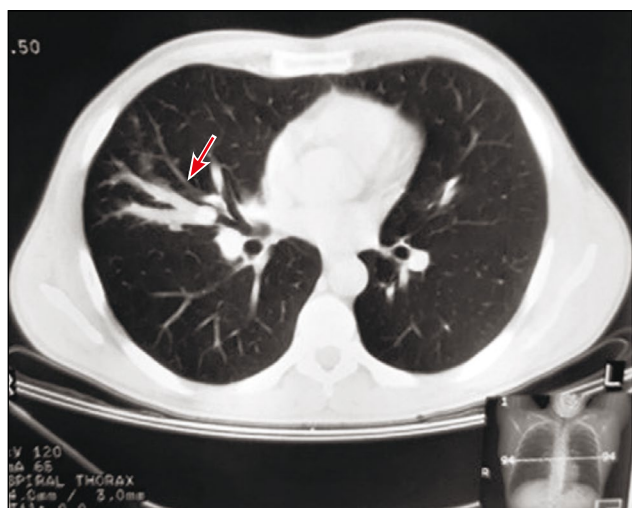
Selective computed tomography scan of the thoracic cavity organs of the same patient: a homogeneous V-shaped structure in the middle lobe of the right lung with clear contours (arrow).
